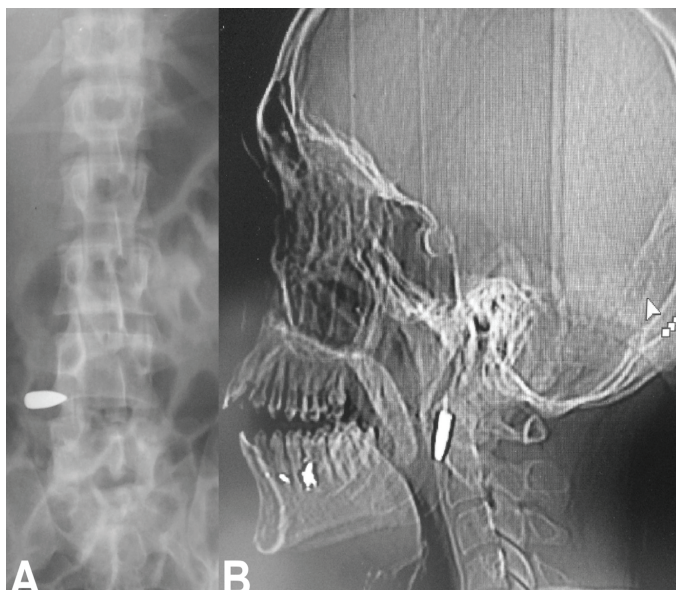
Radiographs of a patient with lumbosacral SGW (A) and cervical SGW (B). There was a bullet just in front of the C1 level (B) SGW: Spinal gunshot wound
